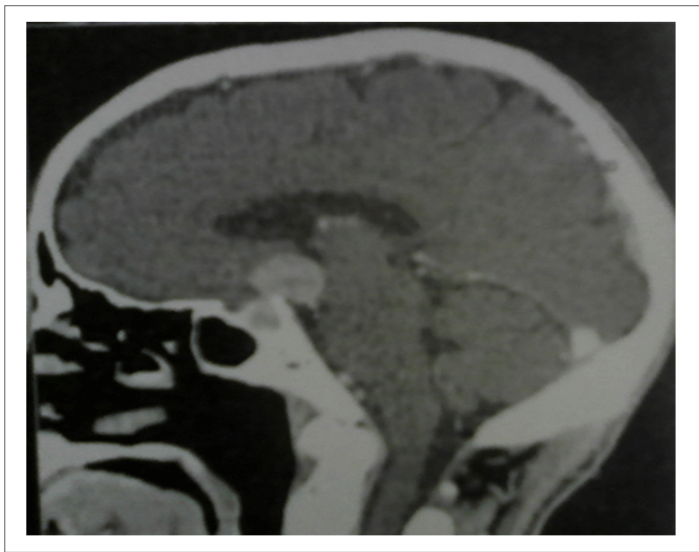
CT scan images showing the hypothalamic metastatic damage (frontal + coronal view)
